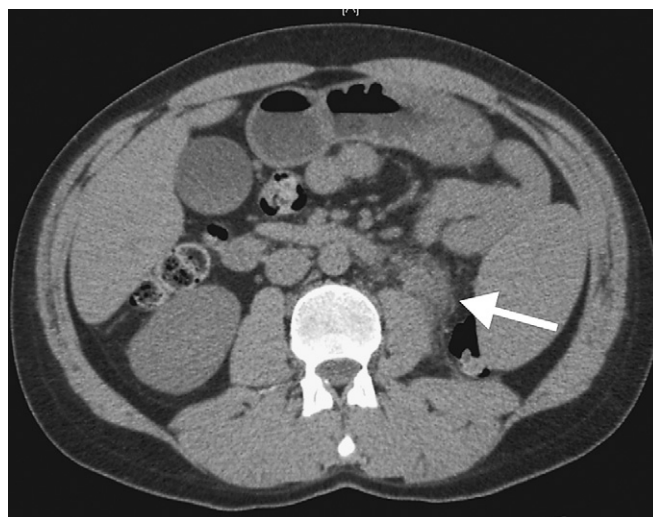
Unenhanced axial computed tomographic image obtained to rule out renal calculi. An atrophic left kidney is visualized with associated fat stranding possibly because of pyelonephritis.
